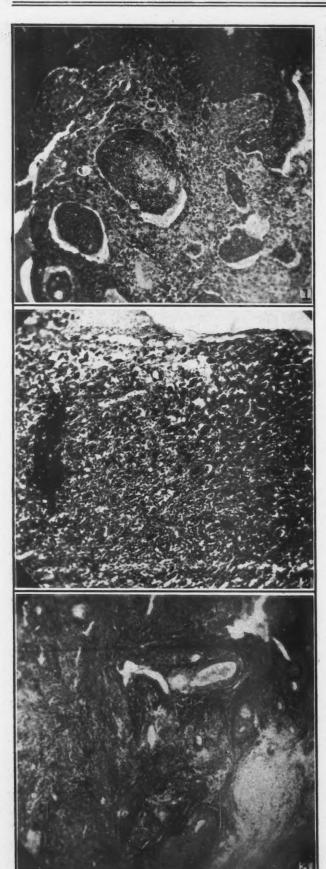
Biopsy from cervix before treatment. Squamous cell carcinoma grade 4. Fig. 2.—One week after beginning of x-ray therapy. Total dose 2,500r. Fig. 3.—The same cervix immediately after the conclusion of the x-radiation, 12,000r having been given. No carcinomatous cells could be found.
